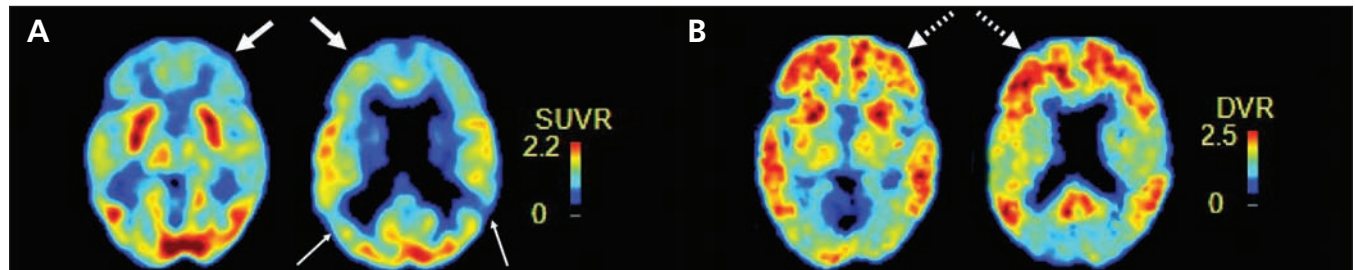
(A) Fluorine-18 deoxyglucose positron emission tomography (PET) of the brain of a 55-year-old man with dementia, showing bilateral frontal (thick arrows) and temporoparietal (thin arrows) hypometabolism, equivocal for Alzheimer disease or frontotemporal dementia. (B) Carbon 11-labelled Pittsburgh compound B PET showing diffuse amyloid binding (dashed arrows) compatible with Alzheimer pathology. DVR = distribution volume ratio, SUVR = standardized uptake value ratio.
